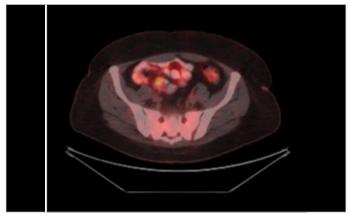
The recurrence disease areas in PET-CT, sacral metastases.
